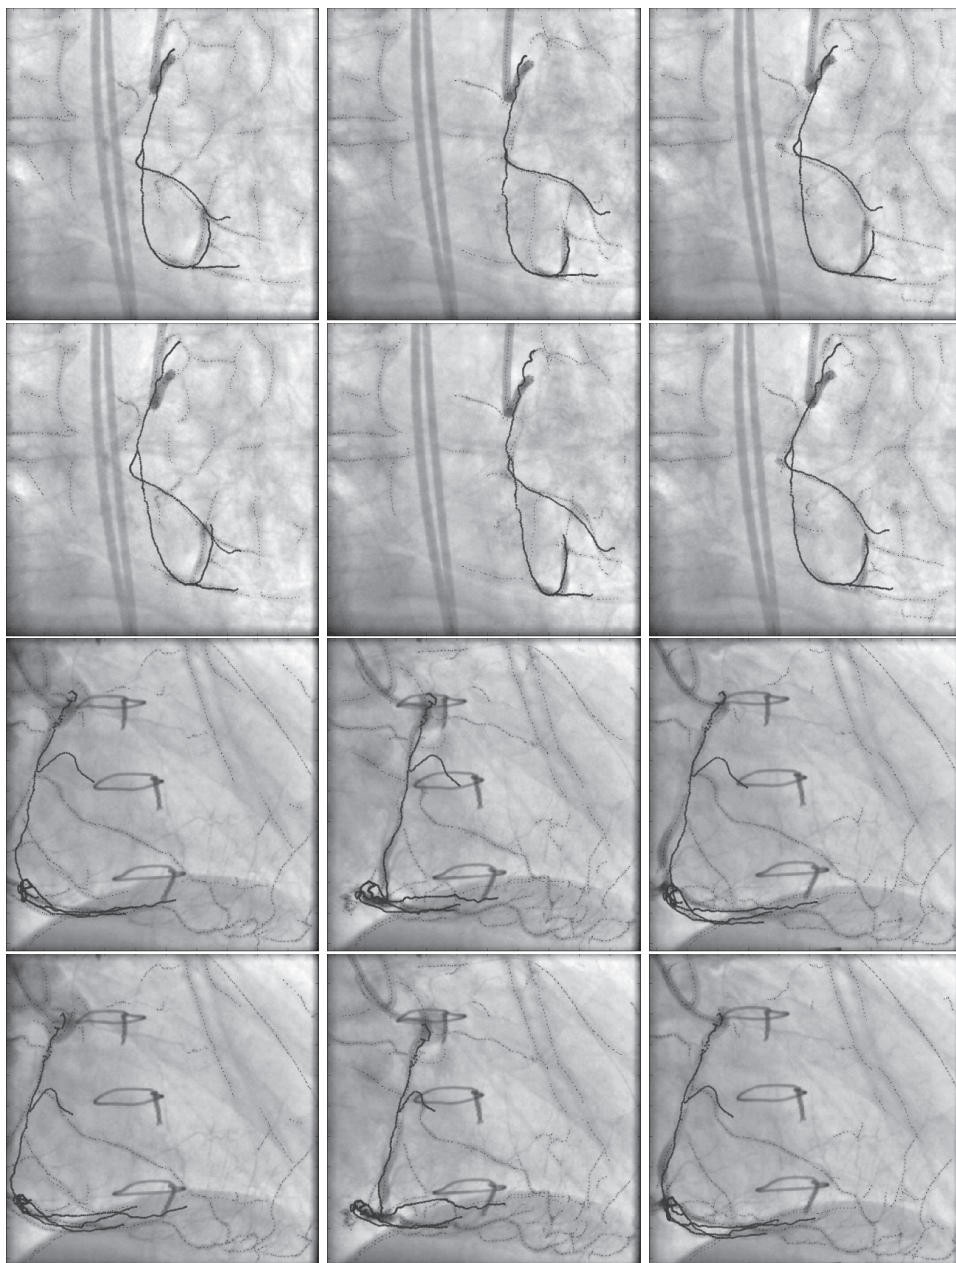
(color version on page 161): 2D+t/3D registration results (continued). Images are taken at 15%, 50%, and 85% of the cardiac cycle. First and third rows use the 4D CTA based coronary motion, the second and last rows use the SMM. A quadratic respiratory model was used in all cases.
